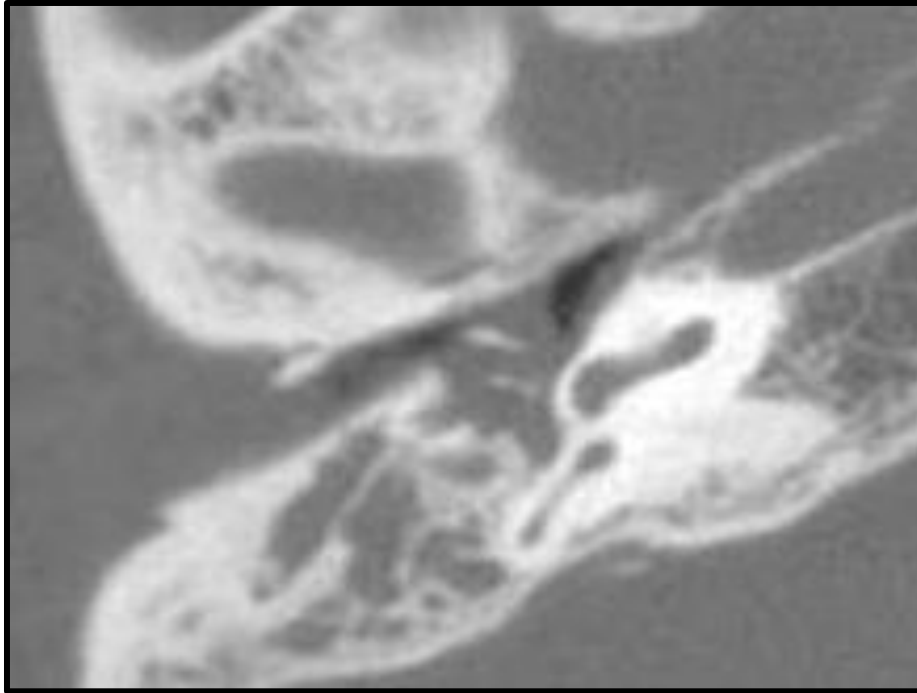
CT scan showed soft tissue shadow occupied in the middle ear and the mastoid cavity
